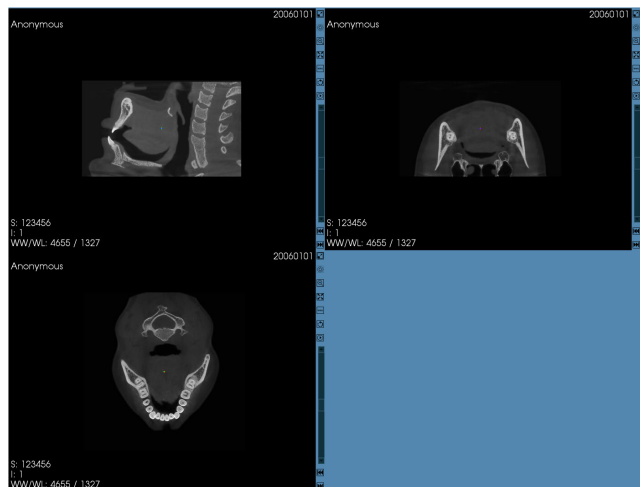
The CBCT scans depict the dento-maxillofacial area, with a predominant focus on the mandible region, as shown in axial, coronal, and sagittal views, respectively.
